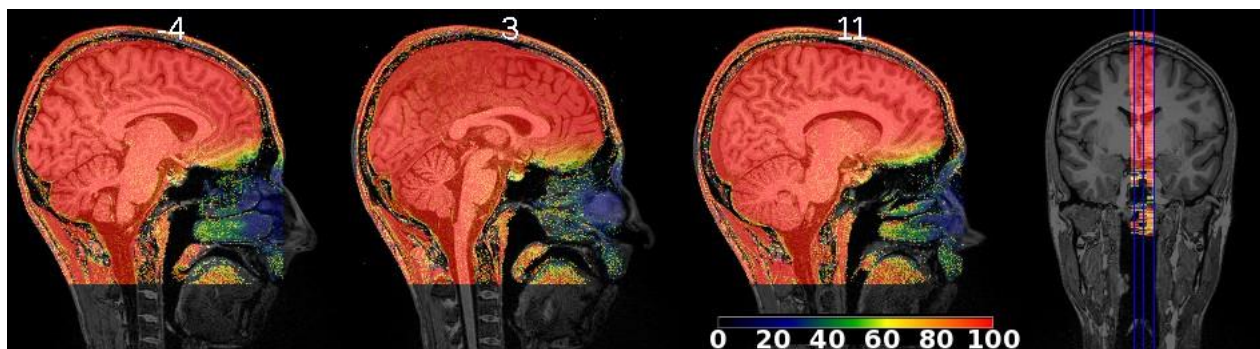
Comparison of the head coils: 30ch vs. 32ch. Proton density weighted images were acquired by using the 30ch and 32ch head coil and after normalization, the former images were divided by the latter ones yielding the procentual signal intensity (100 meaning equal performance). The relative intensity maps have been overlaid on a T1-weighted anatomical image.
